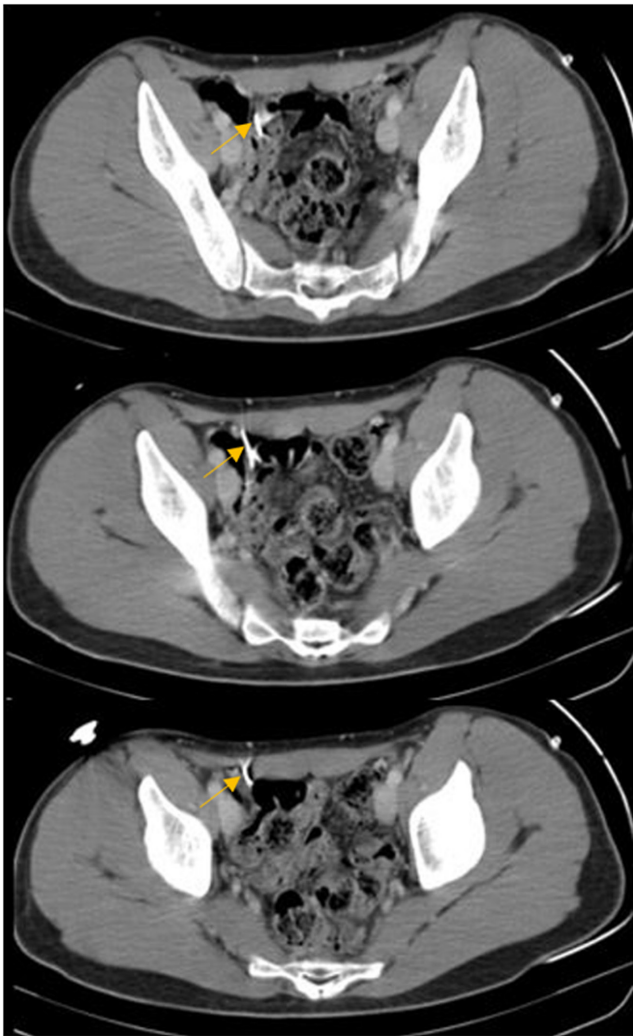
Abdominal CT scan. Nail in the pelvis near bowel loops without pneumoperitoneum or intraperitoneal fluid effusion.
